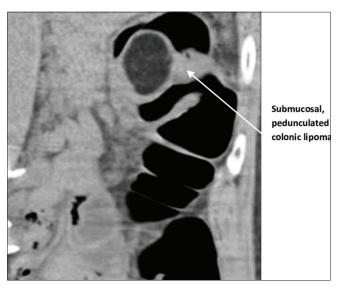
Contrast-enhanced computed tomography showing a 5-cm submucosal, pedunculated, homogenous fat density polyp of transverse colon nearly obstructing its lumen (white arrow)
